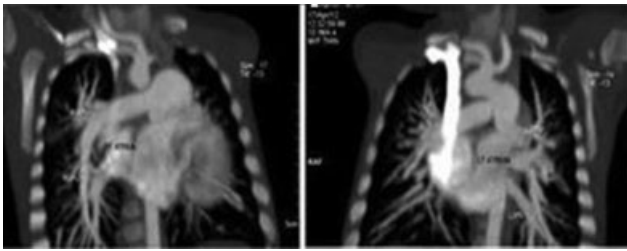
A 5-month-old male child with poor growth and lethargy and cardiomegaly on chest X-ray. MPR images of MDCT show right superior and inferior pulmonary veins are draining into right atrium (marked by a thick arrow) and left superior and inferior pulmonary veins draining into left atrium (marked by a thin arrow). due to partial anomalous pulmonary venous return. MDCT, multidetector computed tomography.
